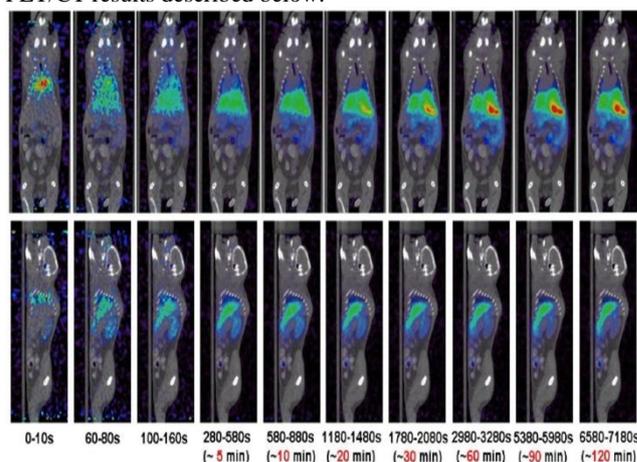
PET/CT result complemented using PRINT carrying a cargo of MR contrast agents.
